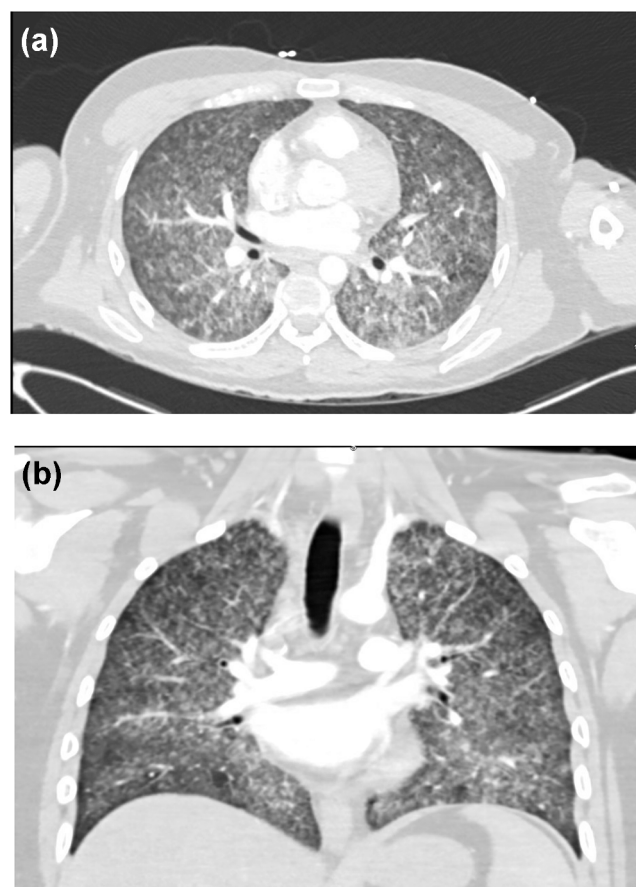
a and b: CTA chest cross-sectional view (a) and coronal view (b) with diffuse extensive symmetrical tiny nodules with central subtle ground glass opacities.
